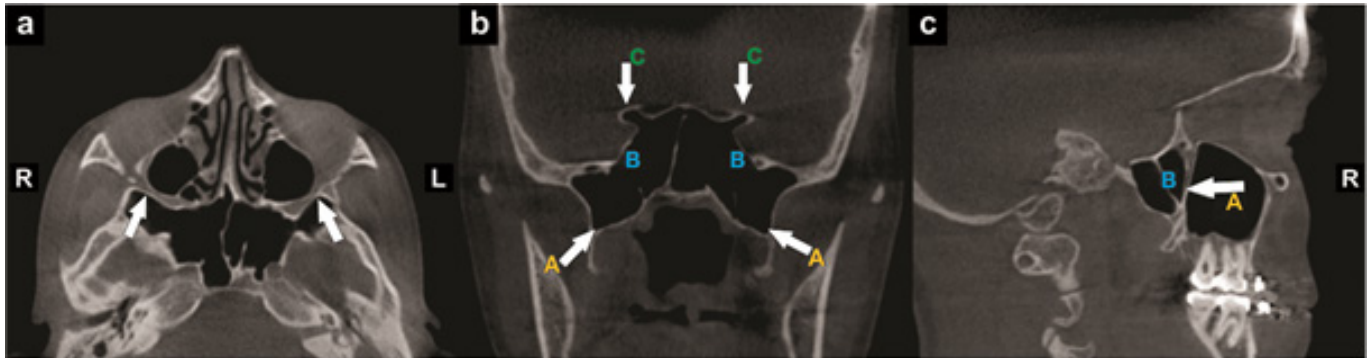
Preoperative CBCT exam for orthognathic surgery: a- axial reconstruction showing the lateral SS'extension, approaching the posterior wall of the maxillary sinus and pterygomaxillary fissure bilaterally; b- coronal reconstruction showing the SS'extension of the full lateral type, involving: (A) pterygoid processes, (B) greater and lesser wings of the sphenoid bone bilaterally + (C) extension to bilateral anterior clinoid process and; c- sagittal reconstruction, showing the SS'pneumatization of the type sellar and (A) approximation of the posterior wall of the maxillary sinus (A) and (B) SS septation of right side.
